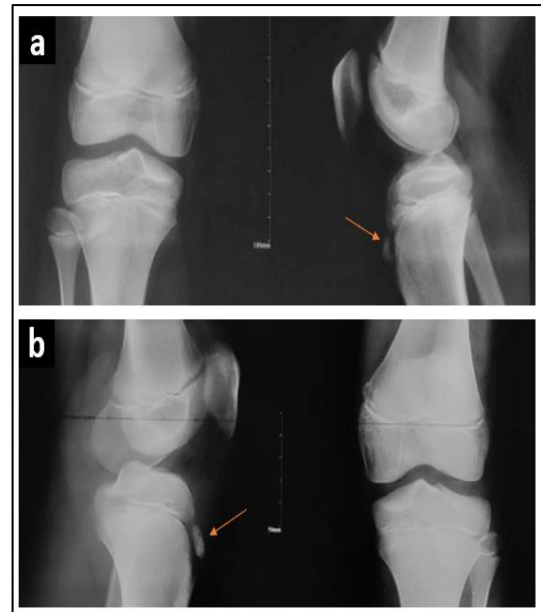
X-ray (antero-posterior and lateral view) of right (a) and left (b) knee of the patient. There is a bone fragmentation (arrow) anterior to the tibia tuberosity with soft tissue swelling.
